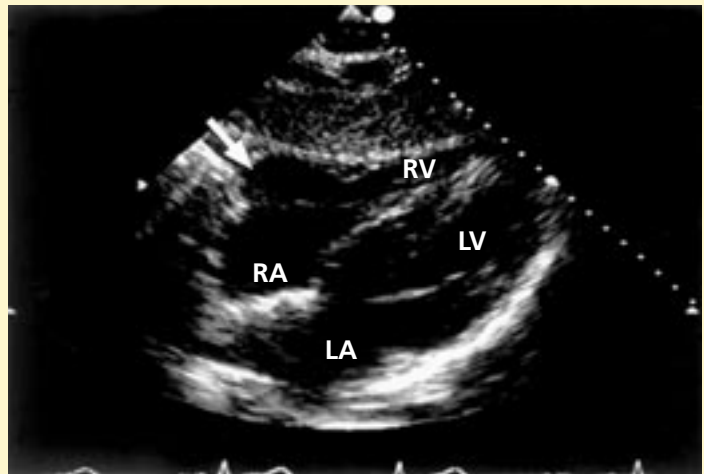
Echocardiogram, subcostal view, demonstrating an outpouching (arrow) at the base of the right ventricle suggestive of arrhythmogenic right ventricular cardiomyopathy (ARVC). RA right atrium, RV right ventricle, LA left atrium, LV left ventricle.
